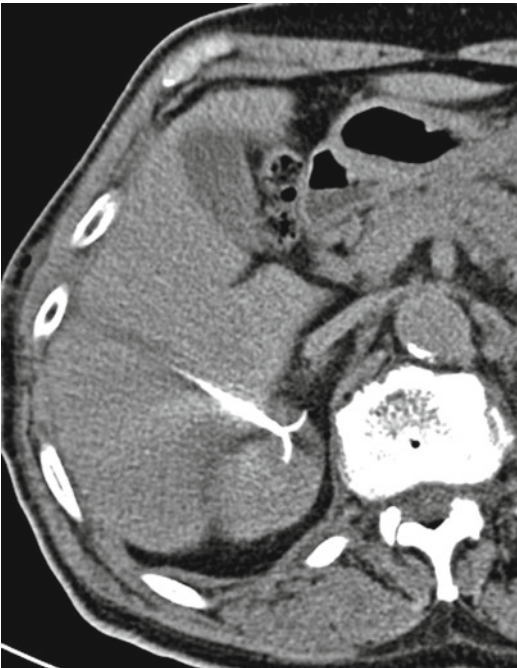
Transhepatic approach to a small renal cell carcinoma for CT-guided RF ablation
